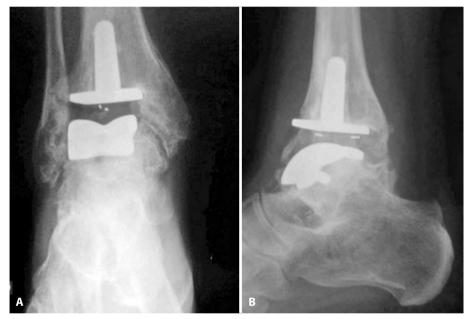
Immediate postoperative X-ray of the right ankle. A: Anteroposterior view. B: Lateral view. Source: Author's personal archive.
